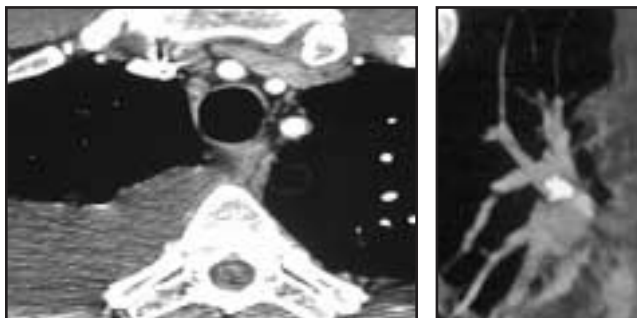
Axial CT image showing a paucity of vessels in the right upper lobe. The corresponding coronal oblique reconstructions and angiogram demonstrate cutoff of the right upper lobe vasculature.
